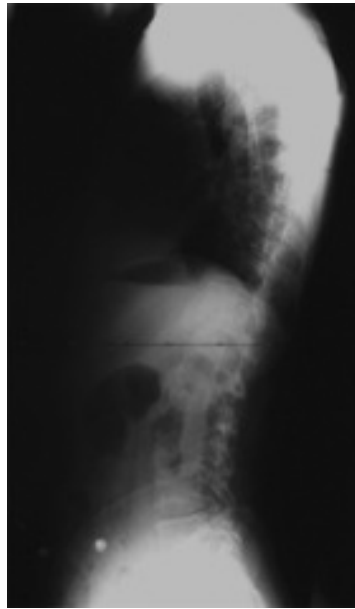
Lateral radiograph of the whole spine demonstrating adequate sagittal balance despite the scoliotic deformity visible on the antero-posterior radiograph.
